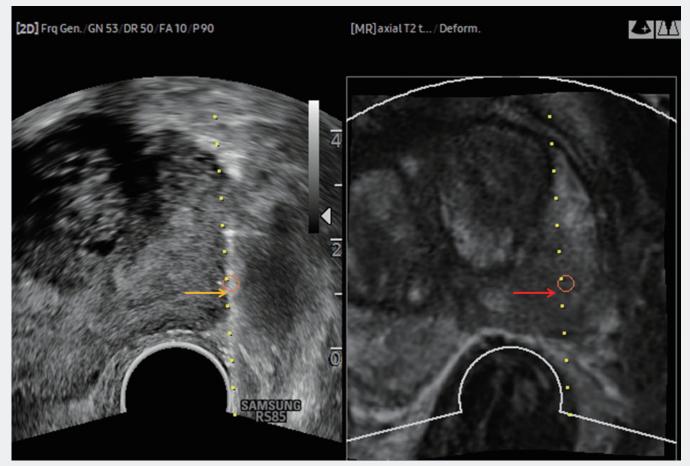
The targeted MR ultrasound fusion biopsy (red and yellow arrows) revealed an acinar adenocarcinoma of the prostate (Gleason 3+4=7a).
